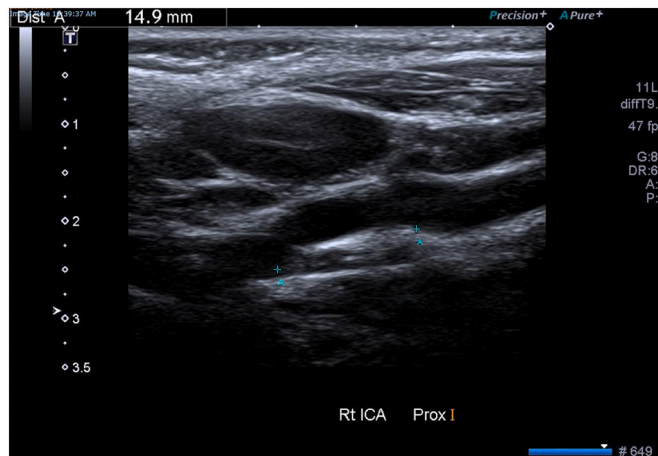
B-mode ultrasound at 2 months demonstrating favourable arterial remodelling with thrombosis of the false lumen with patent true lumen.
